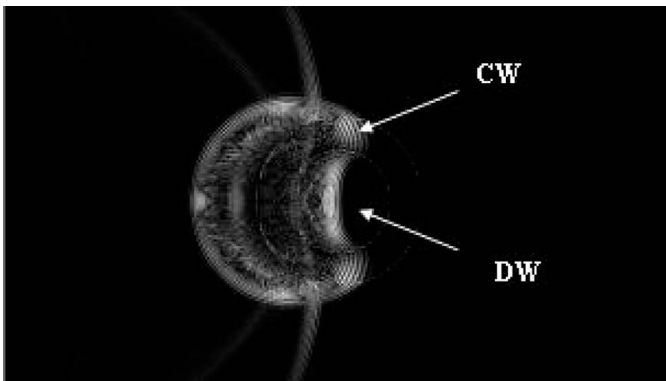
The ultrasound wave propagating (from left to right) through a plastic tube showing a snapshot of the displacement magnitude at $t = 30.9 \mu\text{s}$. Reprinted from *Acoustical Imaging*, vol. 29, 2008, Kaufman J. J., Luo, G. M., Blazy B., Siffert R. S., “Quantitative Assessment of Tubes and Rods: Comparison of Empirical and Computational Results,” with kind permission of Springer Science and Business Media.
